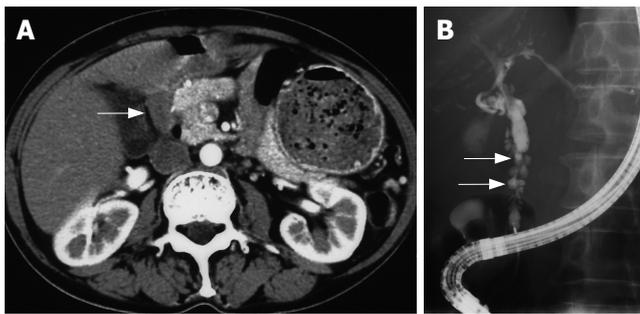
A: Abdominal computed tomography reveals markedly enlarged lymph nodes (arrow); B: Endoscopic retrograde cholangiography shows a bile duct stricture with a diverticulum-like outpouching (arrows).
